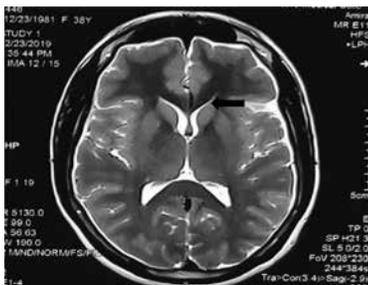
T1 Axial section of MRI of brain – Slit-like frontal horn of left lateral ventricle.
